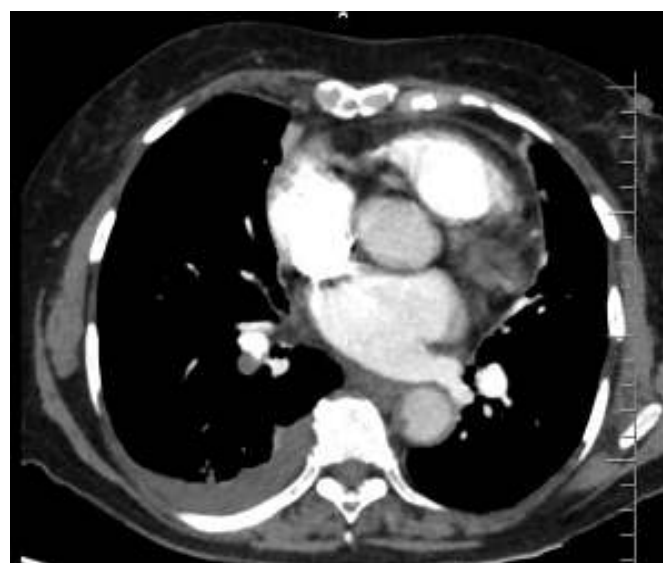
a – Contrast enhanced CT chest – representative mediastinal window image
